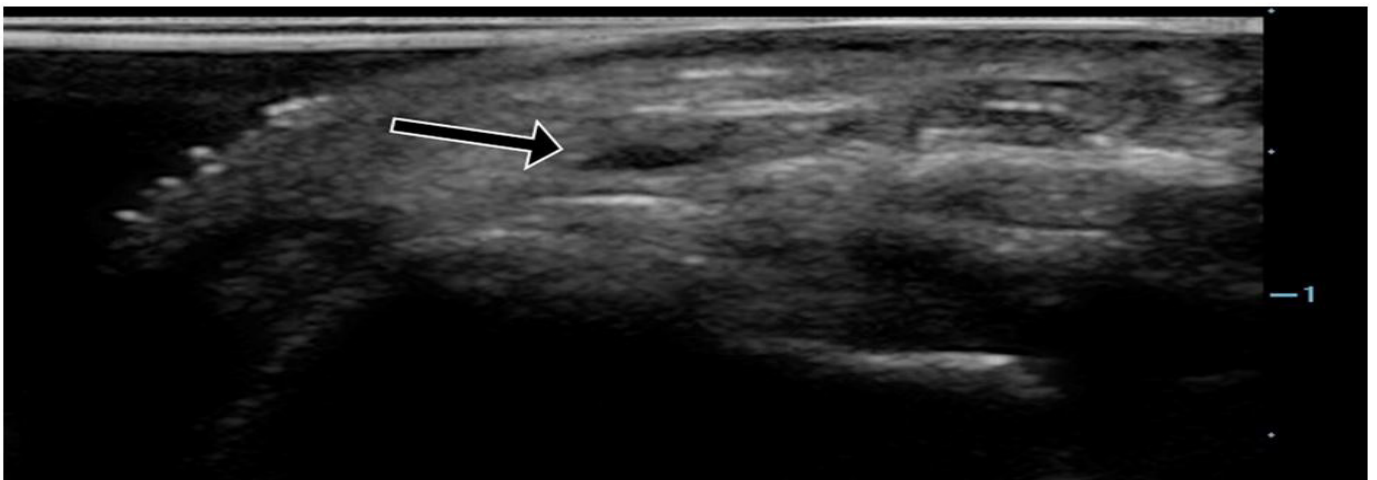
Ultrasound of the radial artery with pressure applied, beginning to show coaptation of the anterior and posterior walls representing diastolic pressure (arrow).
